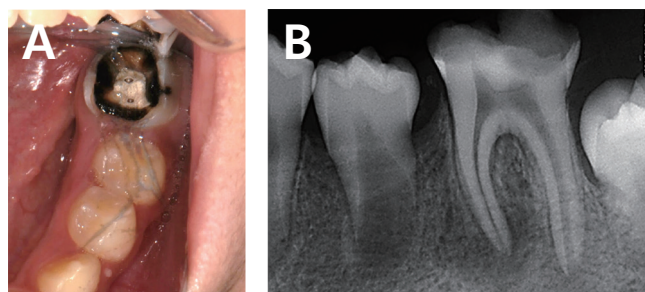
(A) Clinical aspect of the left mandibular first molar in a 9-year-old male patient shows extensive loss of coronal dental tissue, (B) Initial radiographic aspect shows the cavity nearing the pulp.
